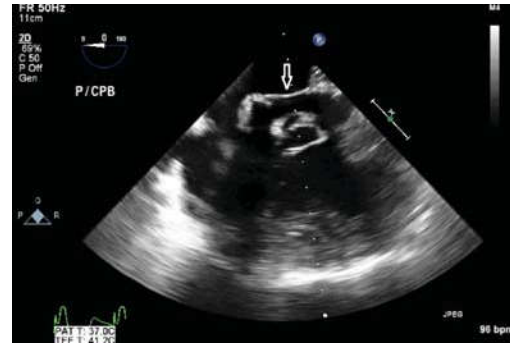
Transesophageal Echocardiographic midesophageal modified midesophageal four chamber view at 0 degree showing a satisfactory surgical repair of the baffle leak as shown by arrow.
